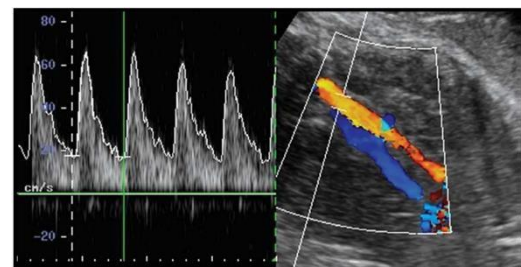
Normal Doppler velocity waveforms obtained from the abdominal aorta [12].
